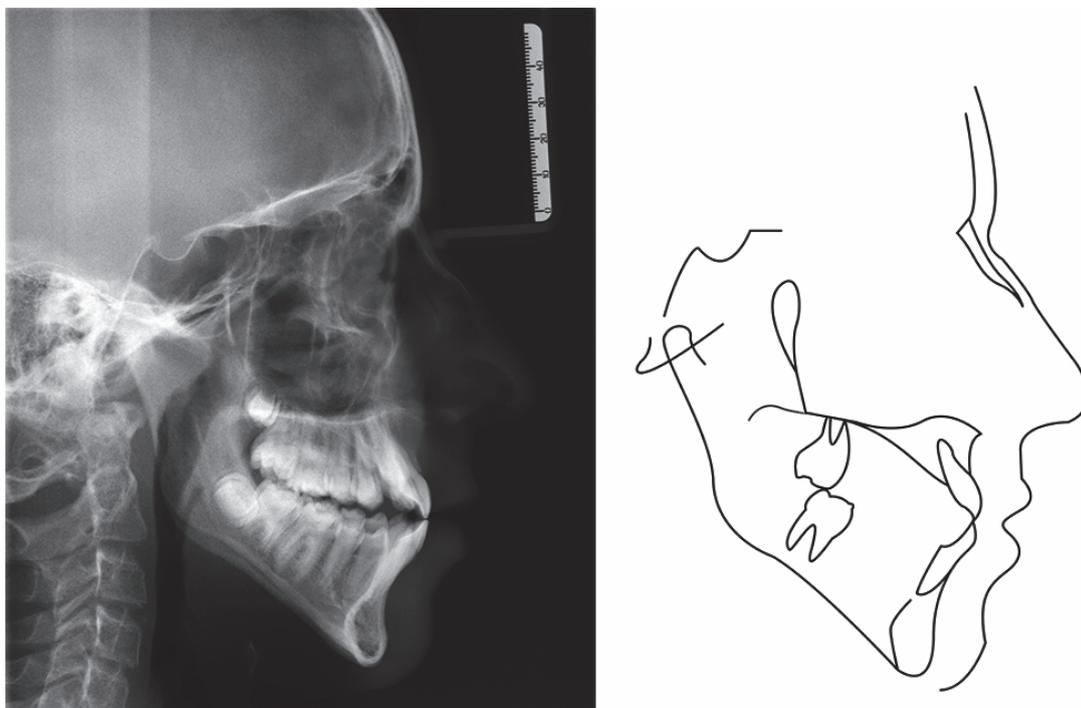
Pretreatment lateral cephalometric radiography and cephalometric tracings.
